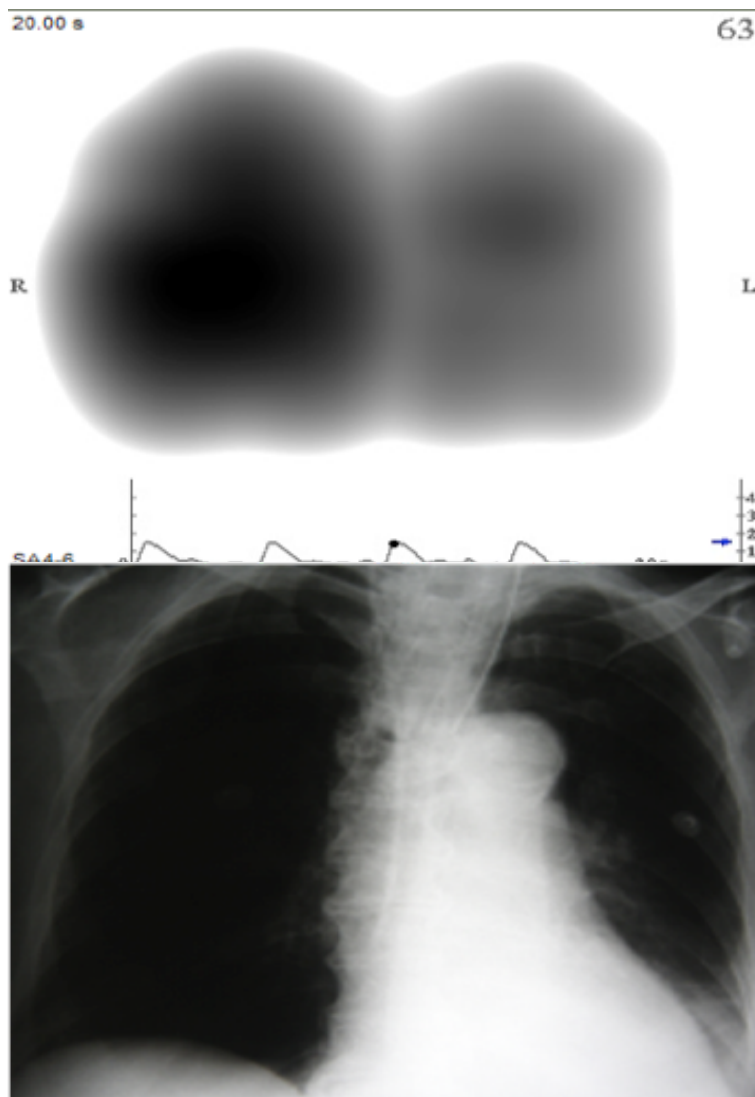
Comparison of findings in VRI and lung x-ray - atelectasis
